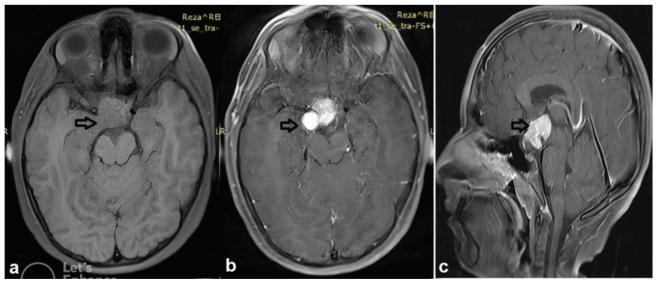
This figure shows the MRI images of the patient; axial cut of T1 images without contrast (a) show a suprasellar isodence solid mass that contain foci of calcification, axial (b) and sagittal (c) cut of T1 images with contrast shows an enhancing lobular mass invaded to surrounding structures. MRI: Magnetic resonance imaging
